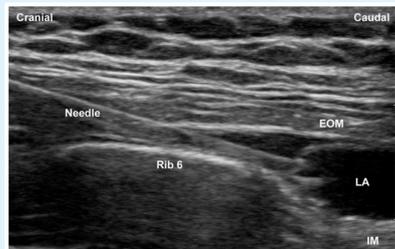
Sagittal ultrasound image of the EOI block.⁶
